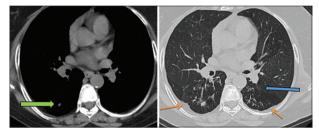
A 30 year old female patient presented with cough, myalgia and shortness of breath for last 7 days. Axial high-resolution computed tomography image (lung window) shows peripherally diffuse ground-glass opacities involving both the lung fields predominantly in right lung field
